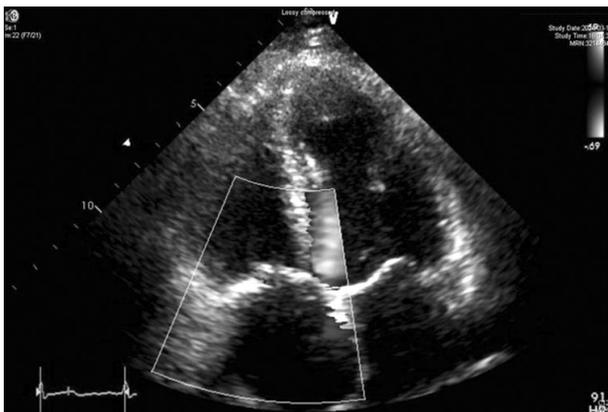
Postoperative echocardiography. Postoperative echocardiography reveals minimal tricuspid regurgitation and no residual mass.
